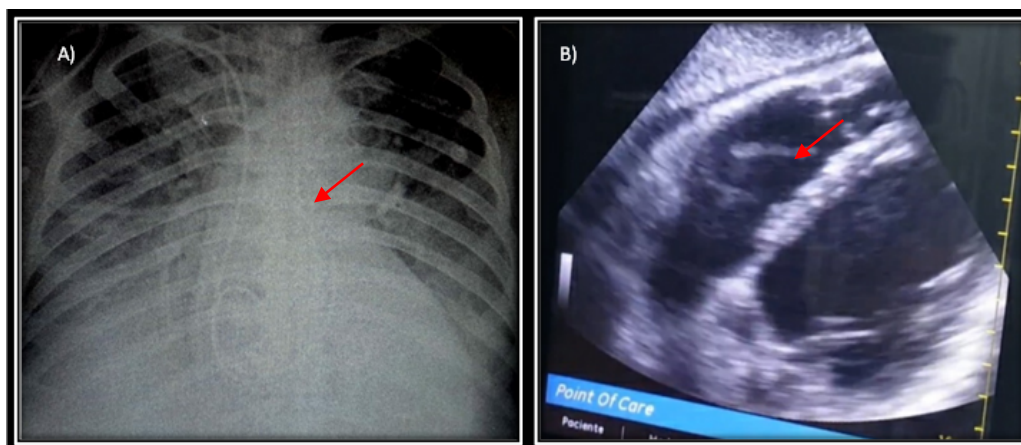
A. Portable chest x-ray, a Swan-Ganz catheter in the pulmonary artery is shown, “red arrow.” B. Subxiphoid ultrasound, where a Swan-Ganz catheter in the pulmonary artery can be seen, “red arrow.”
